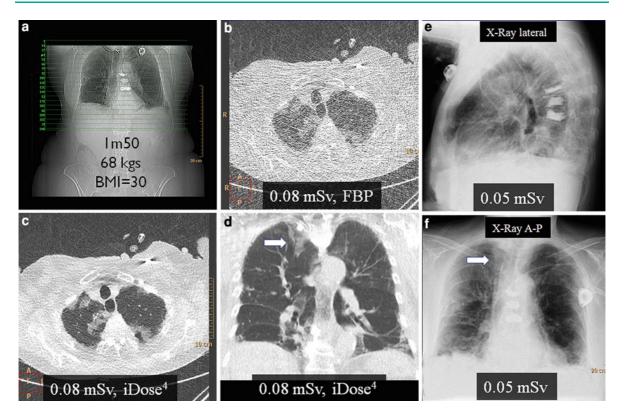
Comparison between ultra low dose chest MDCT and Chest X-Ray. a Surview image used to plan an ultra low dose MDCT scan (80 kVp/10 mAs, DLP = 5.8 mGy.cm, effective dose = 0.08 mSv) performed on a patient with breast cancer (1m50, 68 kg, bmi = 30). The MDCT axial images were reconstructed with b FBP and c iDose⁴ reconstruction algorithms. Images reconstructed with FBP cannot be assessed because of the large amount of noise in the images. However, the images reconstructed with iDose⁴ can be assessed to
